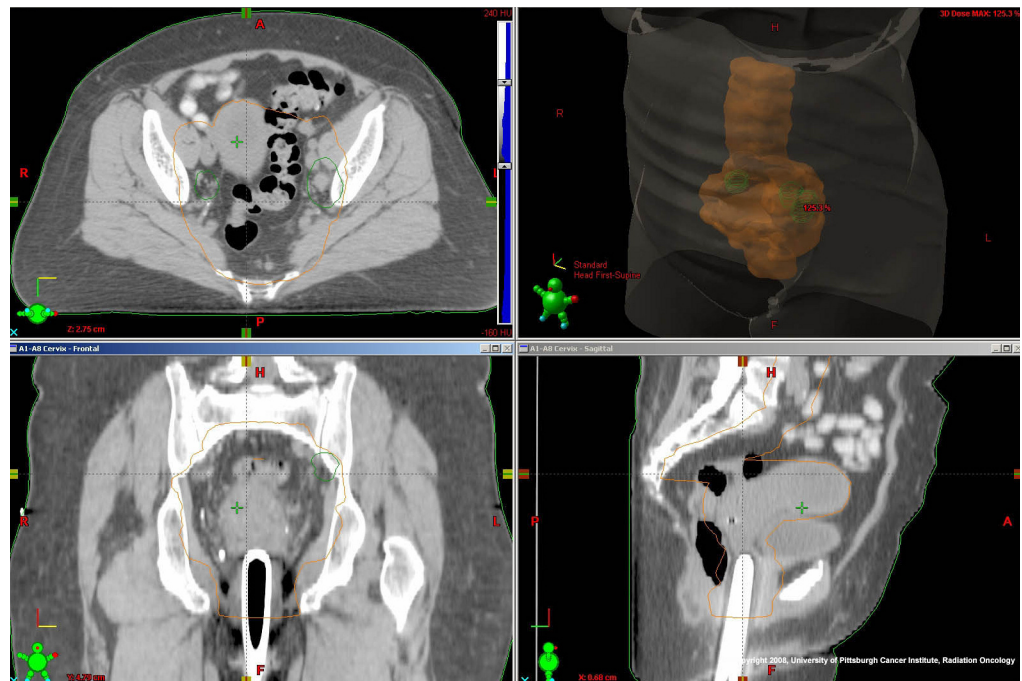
This 4D CT with iso-dose distribution demonstrates coverage of the extended field and shows the treatment field arrangement. *Image courtesy of the University of Pittsburgh Cancer Institute.*
